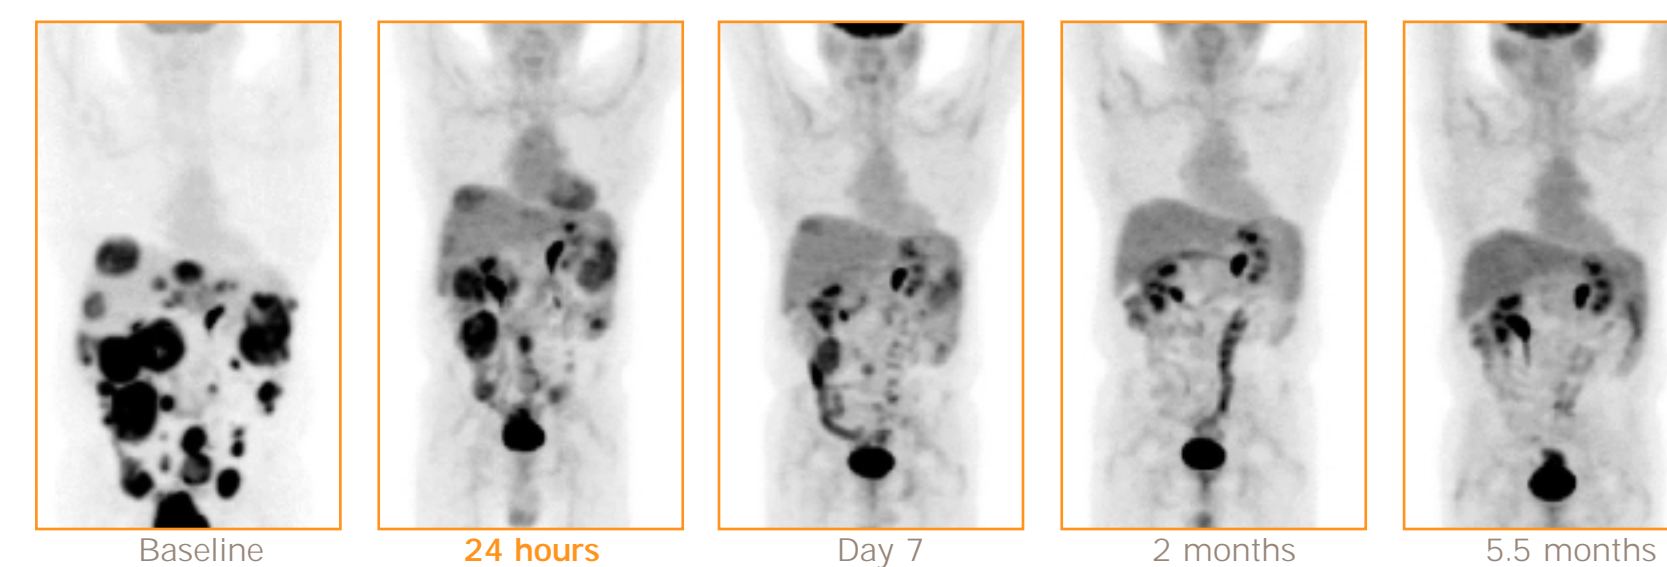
FDG-PET studies in a patient showing extensive, highly FDG-avid abdominal and hepatic disease at baseline. Follow-up studies demonstrate evidence of response as early as 24 hours post-initiation of STI571 therapy, continuing response at 7 days, and no evidence of FDG-avid disease on the 2 and 5.5 months follow-up scans.
